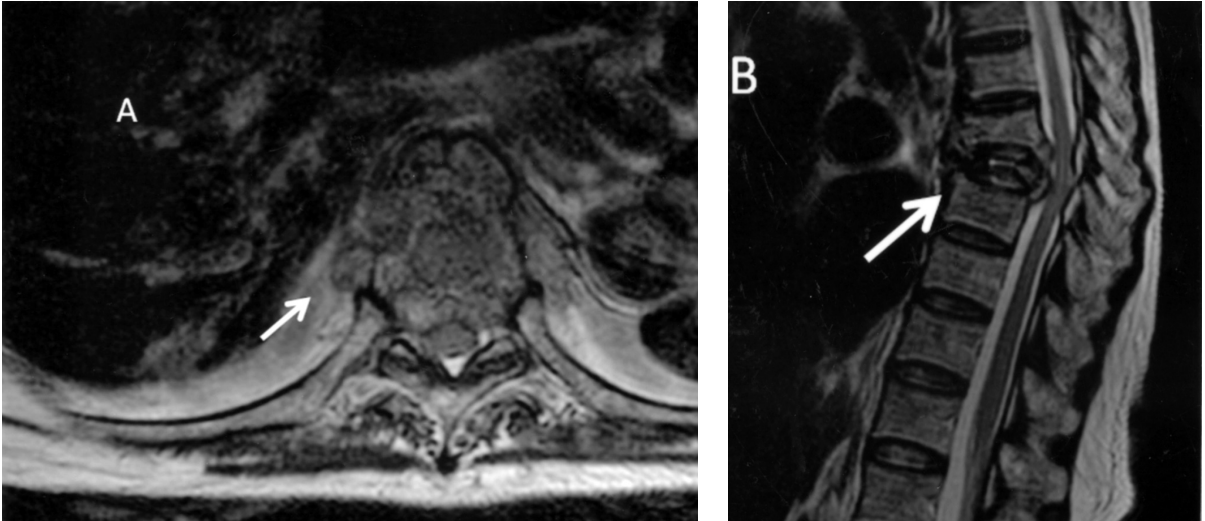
Axial view (A) and sagittal view (B) of the lumbar spine MRI showed a destructive osteolytic lesion of the T8 spine with vertebral body collapse and epidural extension (arrow).
